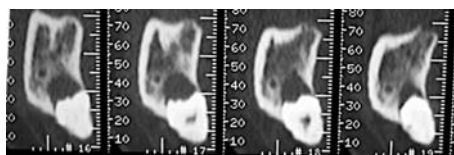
Computed tomography x-ray evaluation is requested to evaluate the anatomical limit of the tooth localized in the right mandible border.
